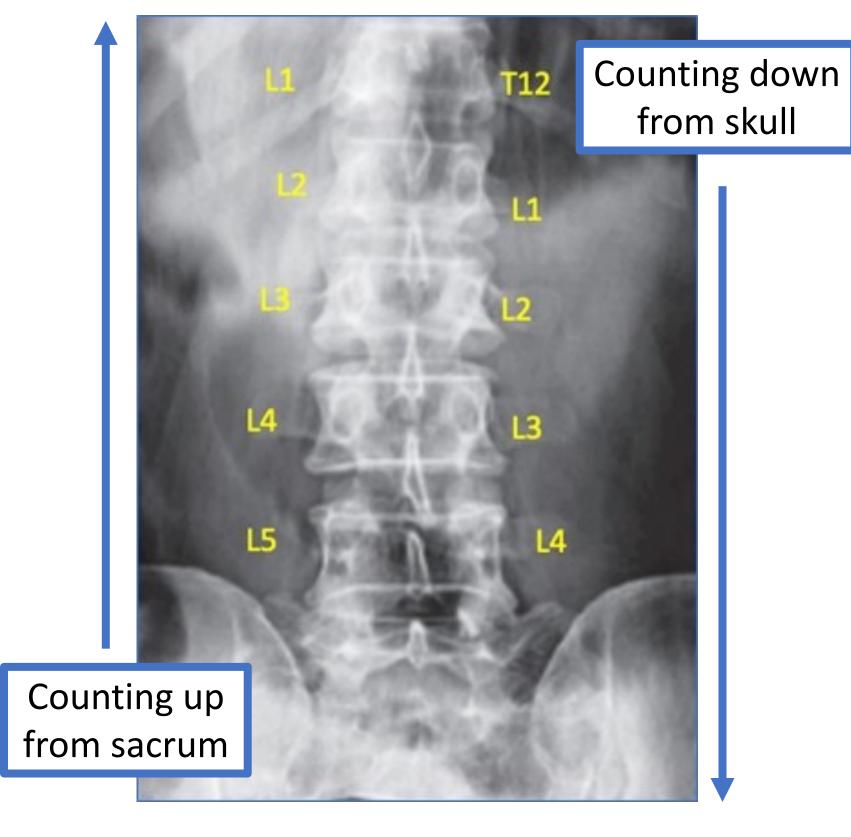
An AP lumbar radiograph demonstrating four non-ribbed presacral lumbar segments numbered in two different ways. The method on the right accounts for the more common abnormality (having 23 presacral mobile segments) rather than the less common abnormality (having 13 ribs).
